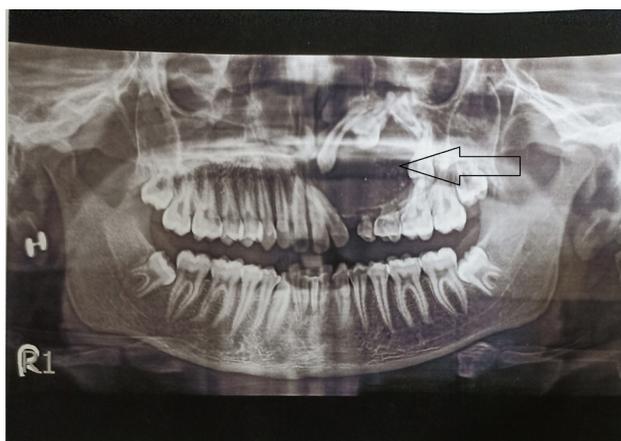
In OPG (Orthopantomogram) unilocular well defined radiolucent cyst seen in left anterior maxillary region
